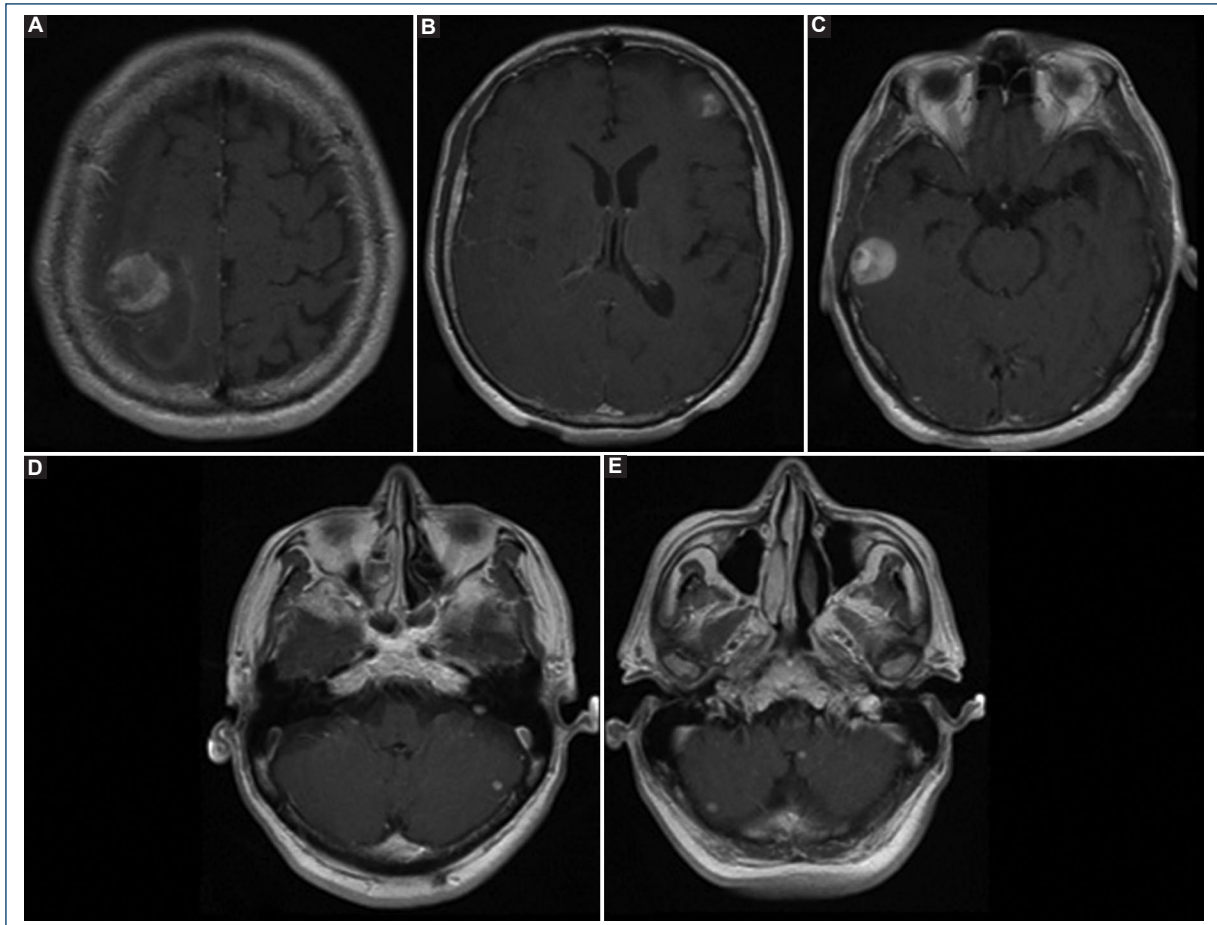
Pre-operative magnetic resonance imaging in the T1 sequence in the axial section A: right frontoparietal lesion of heterogeneous intensity with ring contrast enhancement. B: left frontal lesion. C: right temporal lesion. D: lesion in the left cerebellar hemisphere. E: lesion in the hemisphere right cerebellar and left cerebellar peduncle.
